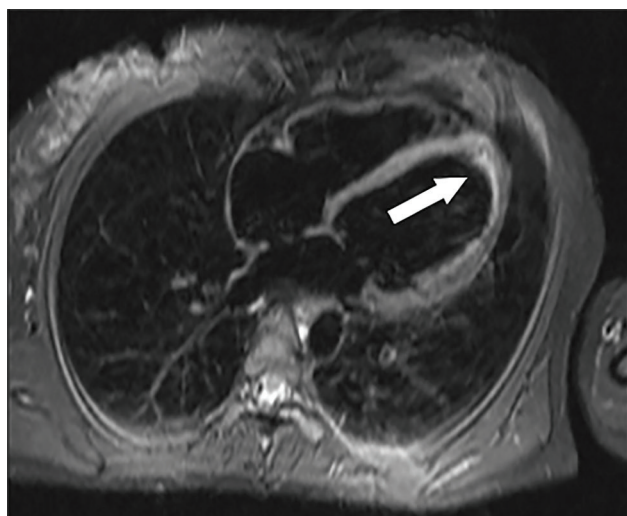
Cardiac MRI one month after COVID-19. Arrow - focal myocarditis in the apical segment of left ventricle.
